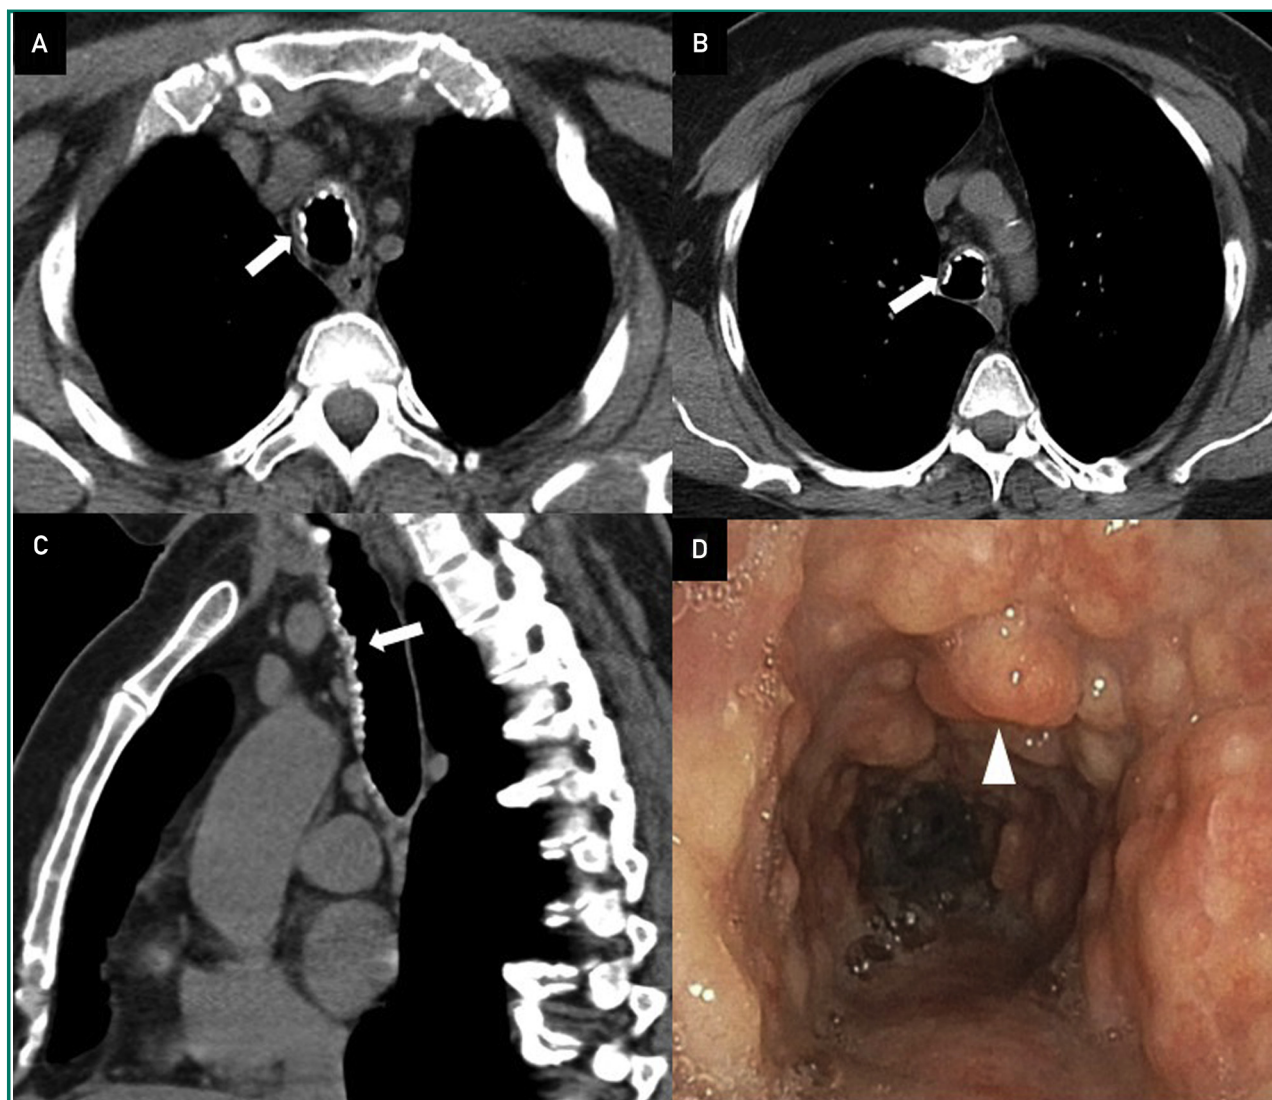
A-C: Non-contrast CT of the chest (axial and sagittal views), demonstrating calcified nodular thickening of the trachea, sparing the posterior wall (arrows); D: Bronchoscopy showing tracheal nodular excrescences sparing the posterior membranous wall (arrow).
